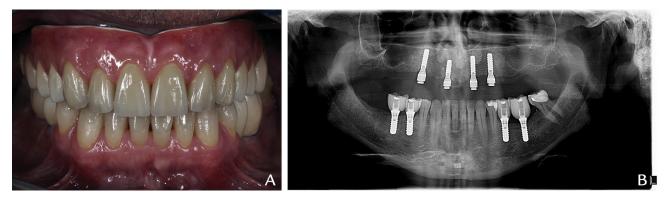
After delivery of restorations. A, Frontal view. B, Panoramic radiograph at 2-year follow-up.
